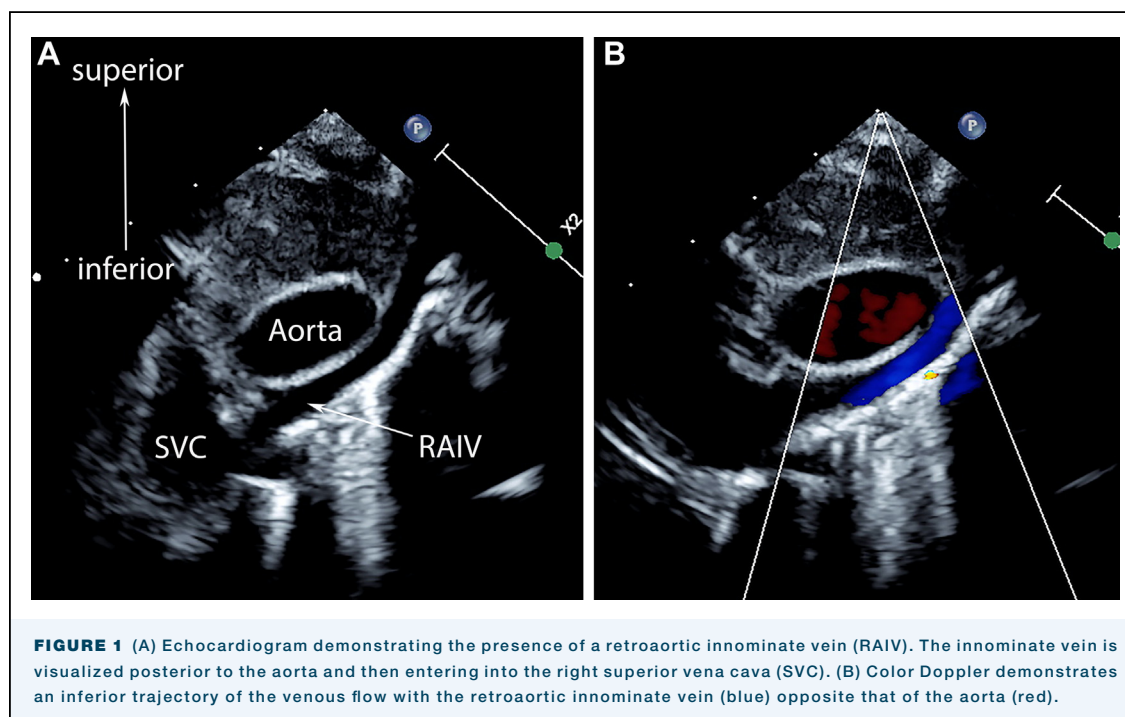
(A) Echocardiogram demonstrating the presence of a retroaortic innominate vein (RAIV). The innominate vein is visualized posterior to the aorta and then entering into the right superior vena cava (SVC). (B) Color Doppler demonstrates an inferior trajectory of the venous flow with the retroaortic innominate vein (blue) opposite that of the aorta (red).
